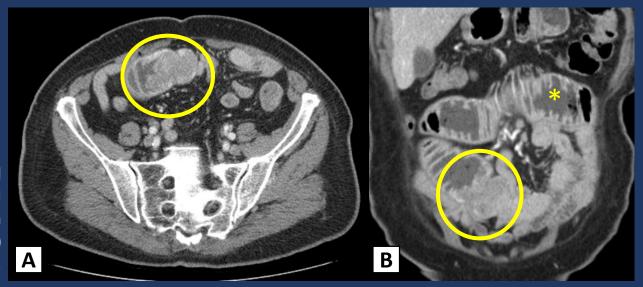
Axial (A) and coronal (B) CT images showing bowel obstruction (asterisk) from a solid and stenotic mass (circle) in a jejunal loop.
